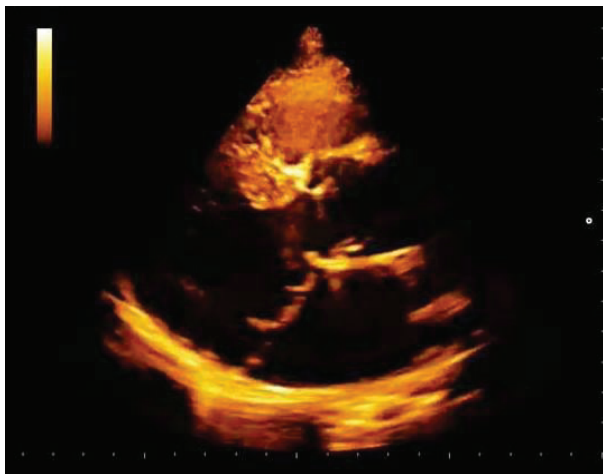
2DTT echocardiogram shows a classical billowing of bileaflets MVP
